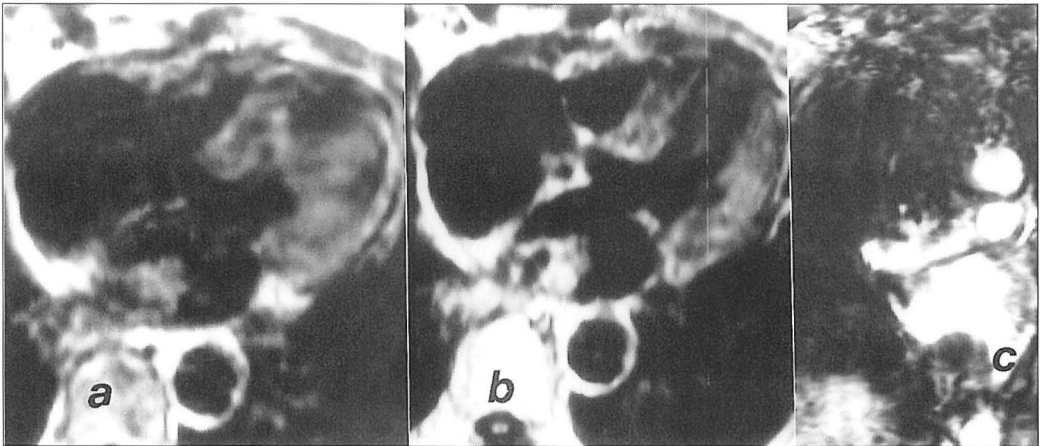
Left atrial myxoma. T1-weighted axial SE images before (a) and after (b) the administration of Gd-DTPA. There is a well-defined inhomogeneous mass in the left atrium attached to the posterior wall. The tumor demonstrates an inhomogeneous enhancement pattern after contrast administration with no enhancement in the medial part. This part has very low signal on the precontrast image, which corresponds with calcification. c Coronal GE image: the myxoma appears strongly hypointense, surrounded by the bright intracavitary blood.
